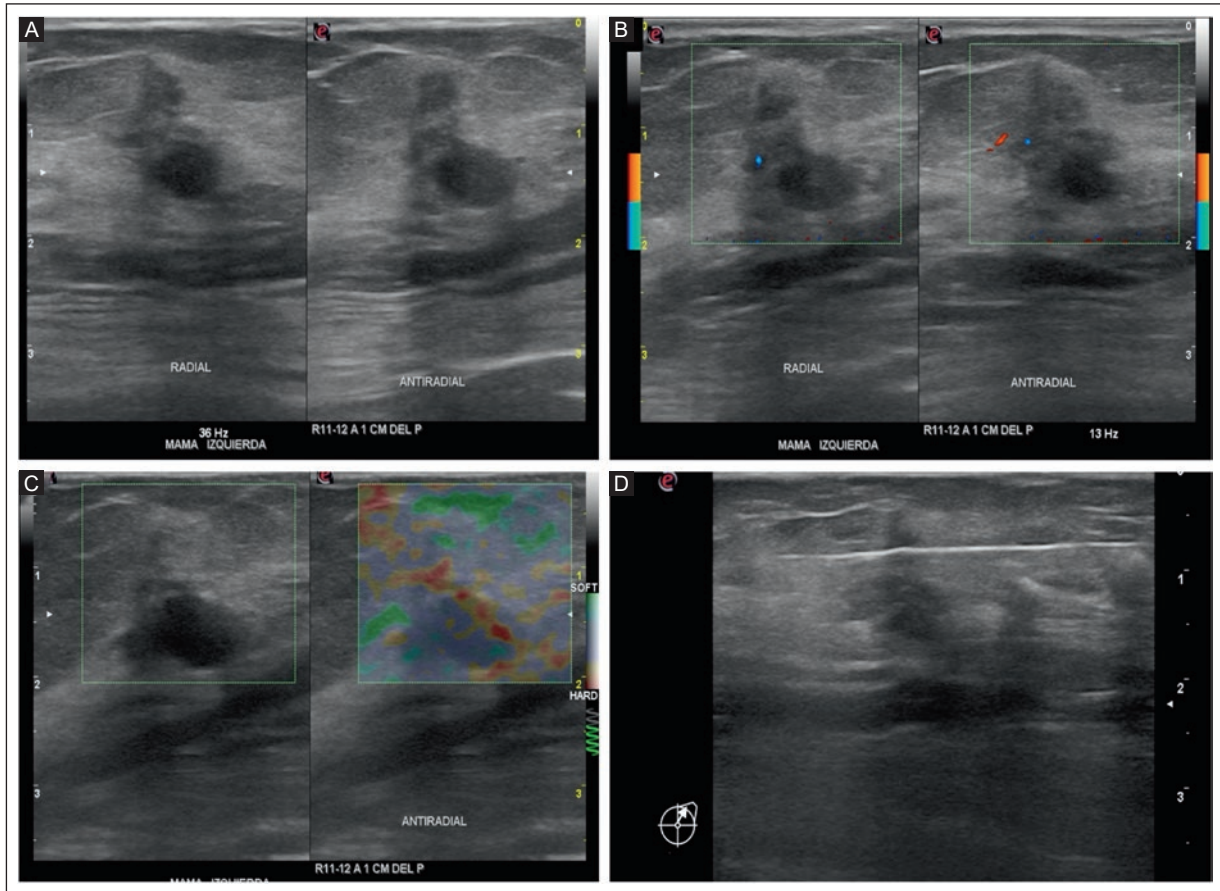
US of a 74-year-old woman with synchronous bilateral breast cancer. A: a grayscale US of the left breast in radial and antiradial view shows a hypoechoic, non-parallel, irregular mass with an angular margin. B: peripheral vascularity on color Doppler US. C: rigid qualitative elastography, BI-RADS 5. D: a hyperechoic needle is seen in the mass during the biopsy. Lymph nodes with normal US features were found in both axillary regions.
